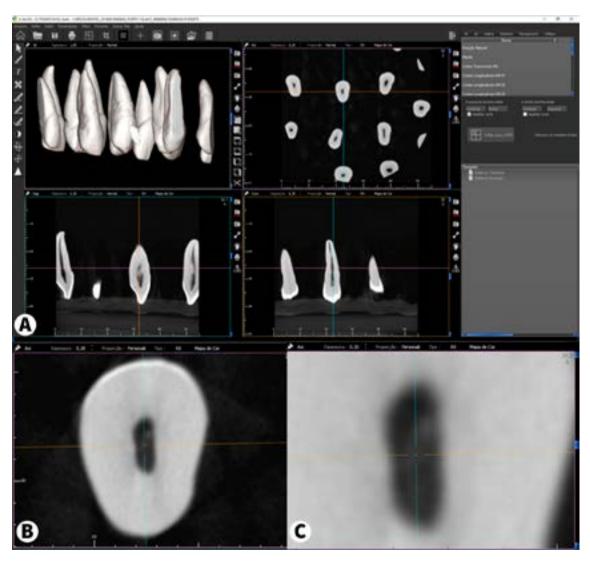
(A) Initial presentation of CBCT reports with slices in multiplanar reconstruction (MPR); (B,C) greater magnification of the image A in axial slice.
